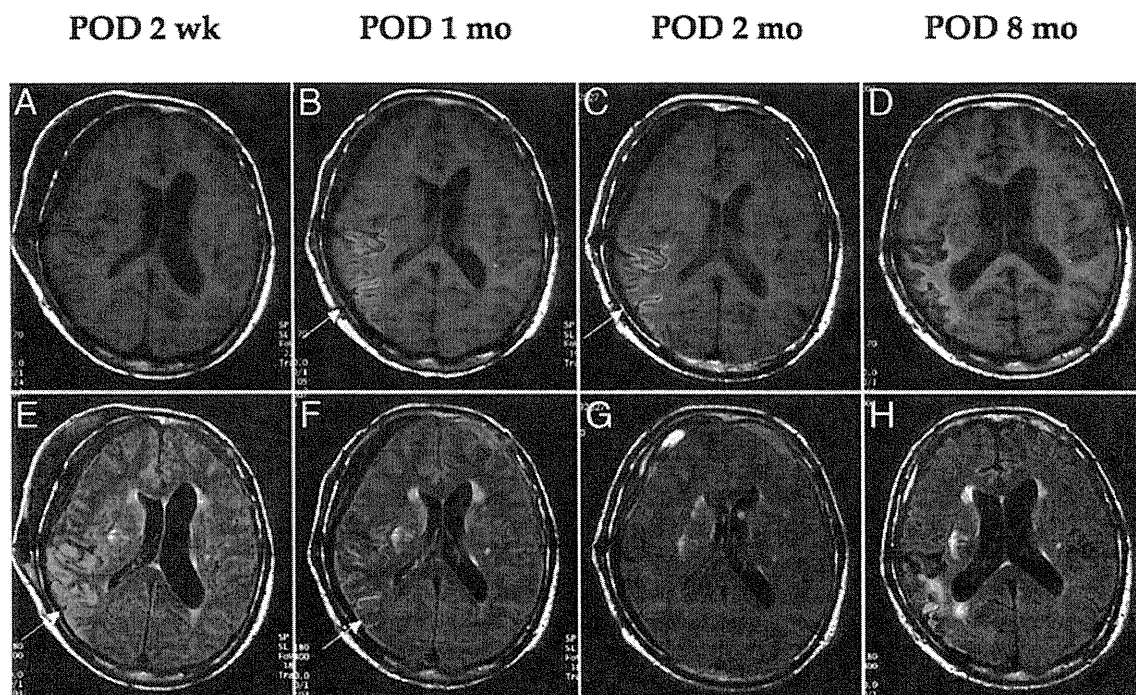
Chronological changes demonstrated on follow-up MR images. Sagittal T1-weighted images (A–D) showing emerging cortical hyperintensity of the affected cortex between 2 weeks after surgery (POD 2 wk; A) and 1 month after surgery (POD 1 mo; B); the hyperintensity becomes more prominent at 2 months (POD 2 mo; C). Cortical laminar necrosis indicates atrophic change in the late chronic stage (D). E–H: On FLAIR images, cortical hyperintensity gradually decreases from 2 weeks after surgery (POD 2 wk; E) to 1 month after surgery (POD 1 mo; F) postoperatively and almost disappears by 2 months (POD 2 mo; G). In the late chronic stage, cortical atrophy with secondary degeneration of the underlying subcortical white matter is noted (H).
